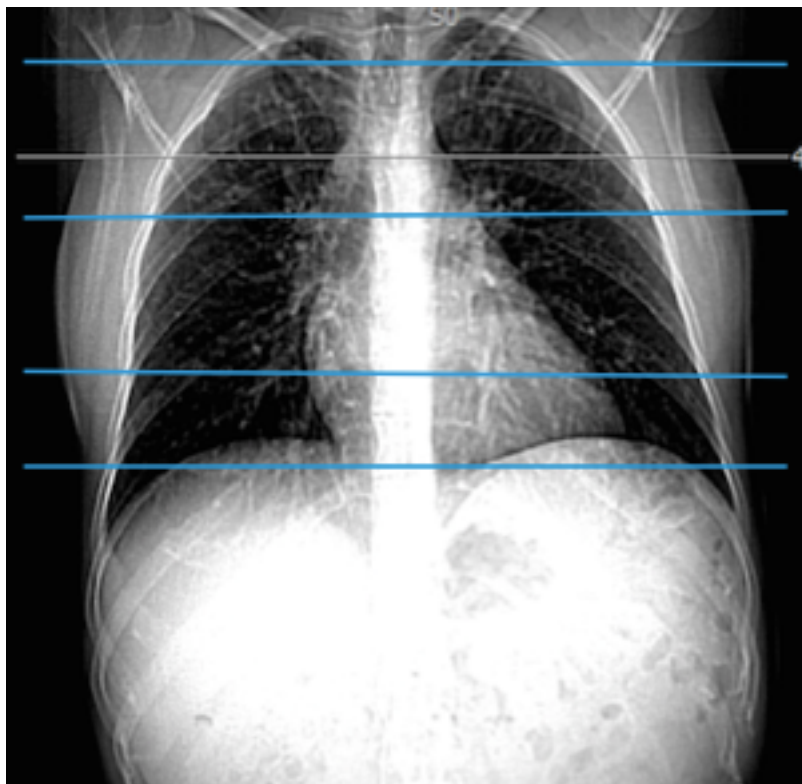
Anteroposterior scanned projection radiograph used to identify 5 levels at which images were acquired for the 7-section low-dose protocol.
